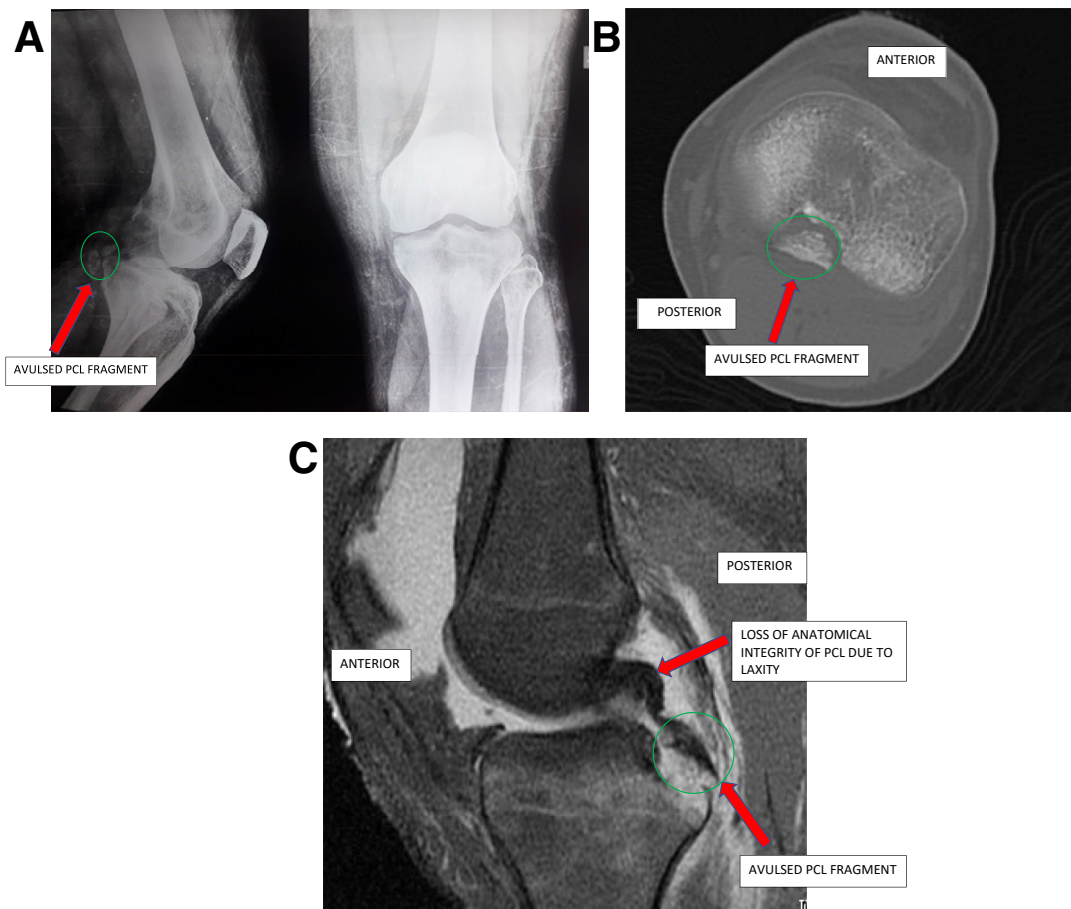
(A) Anteroposterior and lateral radiographic views of knee showing avulsed posterior cruciate ligament (PCL) fragment. (B) Axial-view computed tomography showing avulsed PCL fragment. (C) Sagittal-view magnetic resonance imaging of knee joint showing PCL avulsion.
